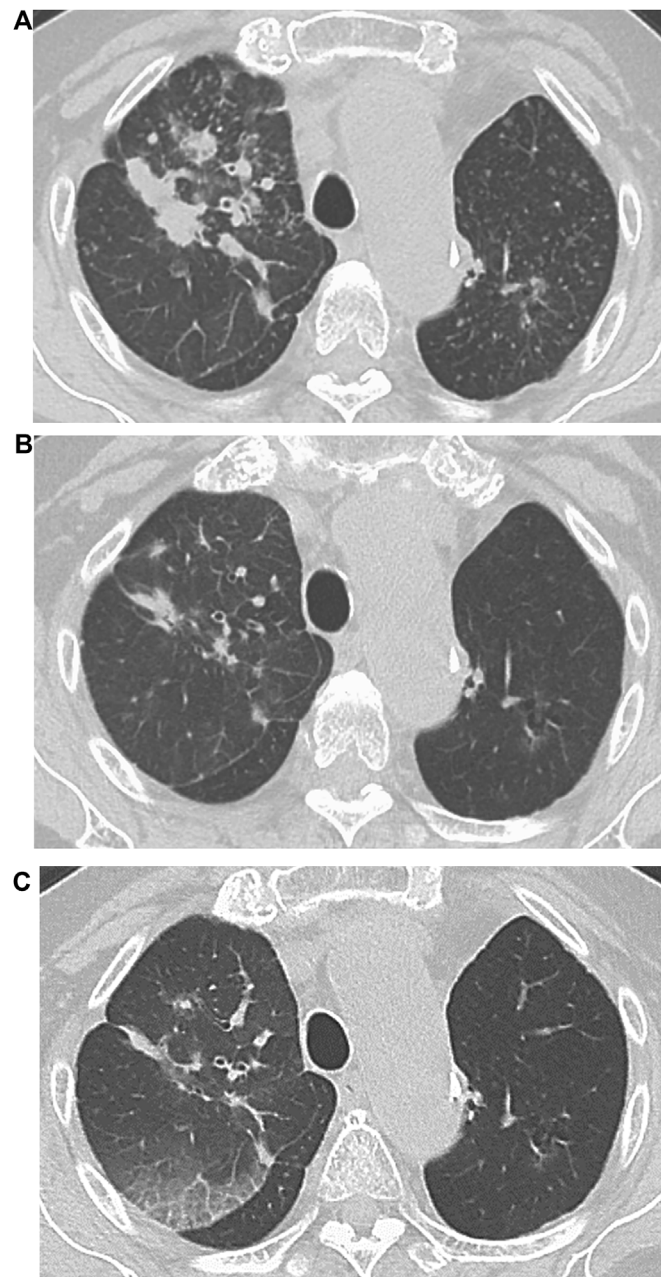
Chest computed tomography scan. (A) Before treatment with osimertinib, the scan showed the multiple nodules in the right upper lobe of the lung. (B) Two weeks after initiation of osimertinib, the scan showed remarkable remission of the tumor. (C) Two months after initiation of osimertinib, the scan showed visible ground-glass opacities in the right lung.
